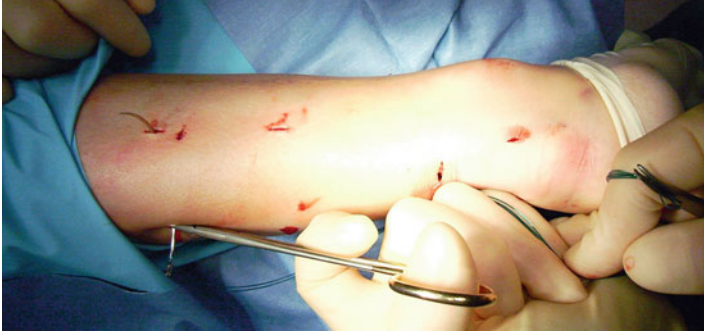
A 9 cm Mayo needle (BL059N, #B00 round point spring eye, B Braun, Aesculap, Tuttlingen, Germany) is threaded with two double loops of Number 1 Maxon (Tyco Healthcare, Norwalk, CT), and this is passed transversely between the proximal stab incisions through the bulk of the tendon
